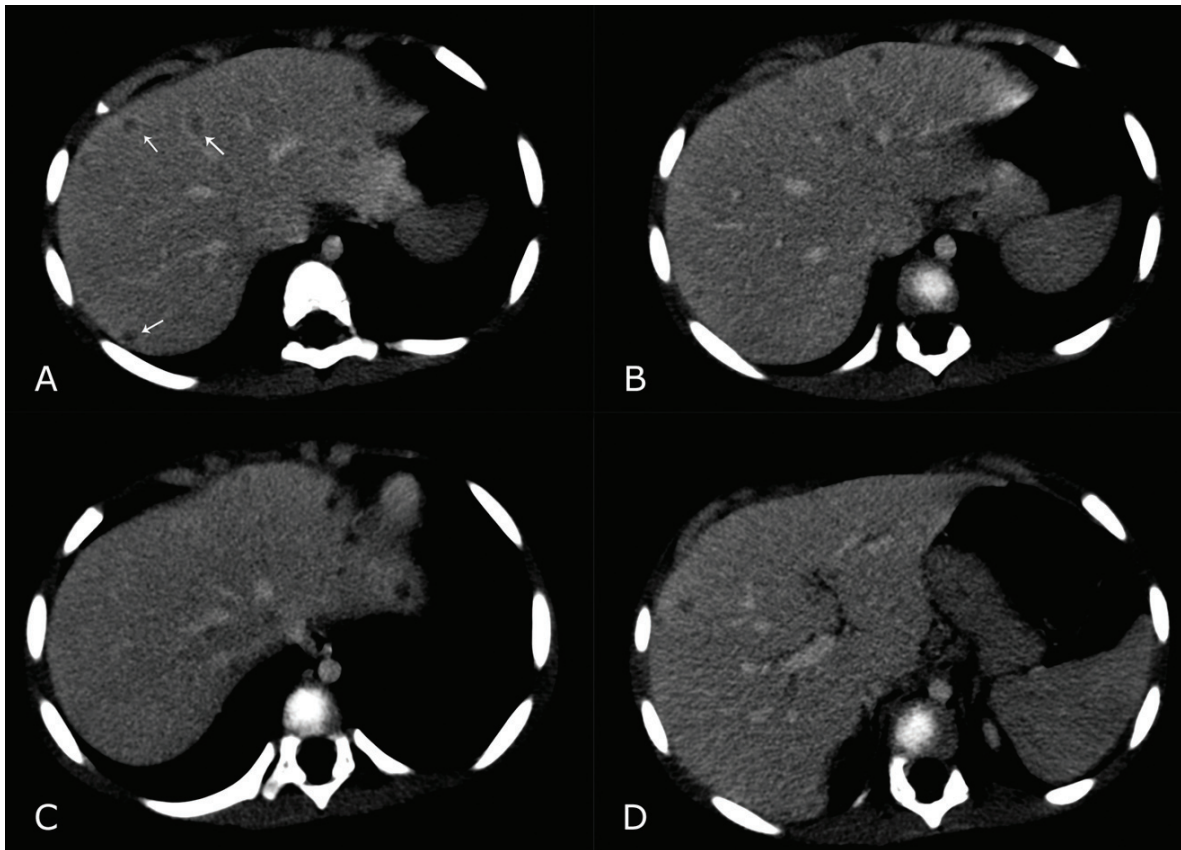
Abdominal CT after intravenous contrasted medium. Note in A, B, C and D – multiple hypoattenuating, small and round lesions – some of which are presented with a white arrow in A.
